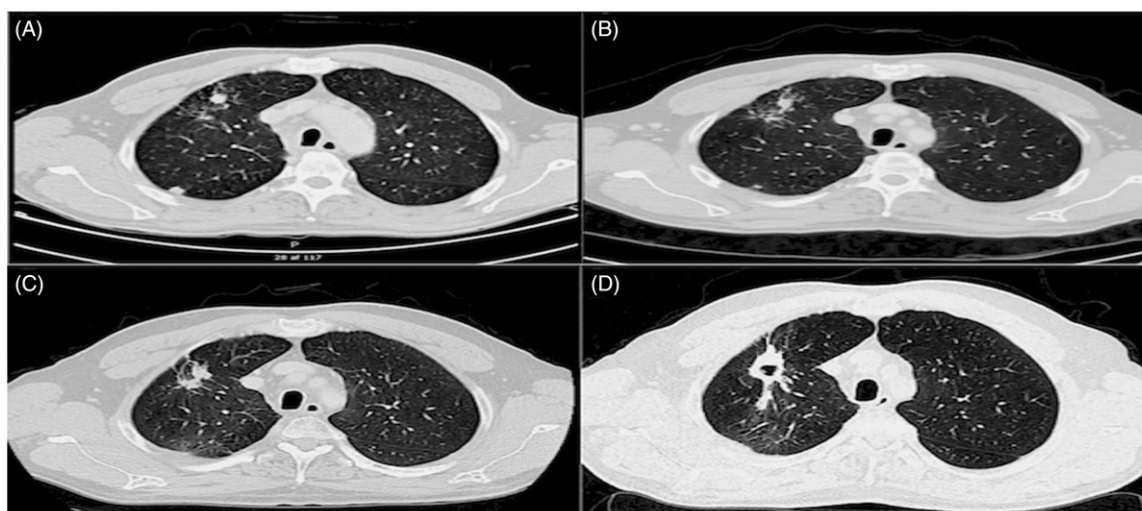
Axial contrast enhanced CT images of both primary infiltrates in the right upper lobe from different time points throughout the clinical course of the patient: before concomitant chemoradiation (A), two-months post-chemoradiation (B), before treatment with nivolumab (C), and after 12 cycles of nivolumab (D).
